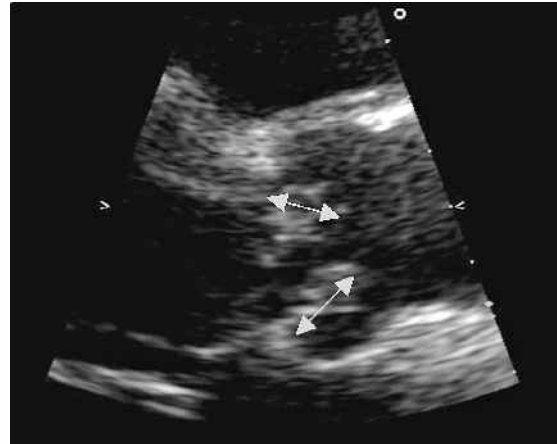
Transthoracic echogram (long axis view) shows aortic valve vegetations (marked with arrows).
